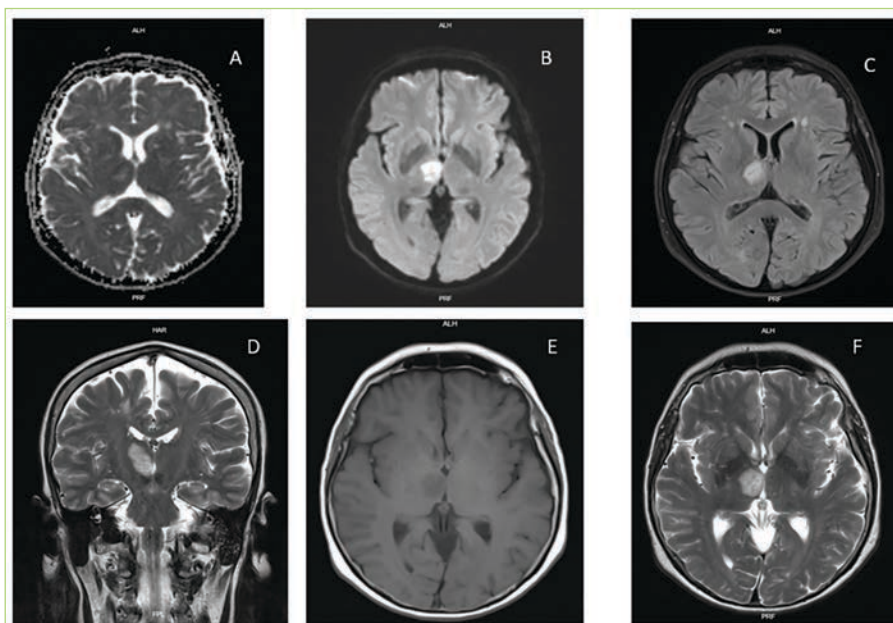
Brain magnetic resonance imaging (MRI) sequences
